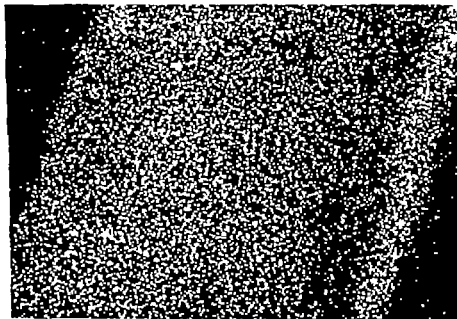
X-ray image by SKa at the same site in Fig. 4
